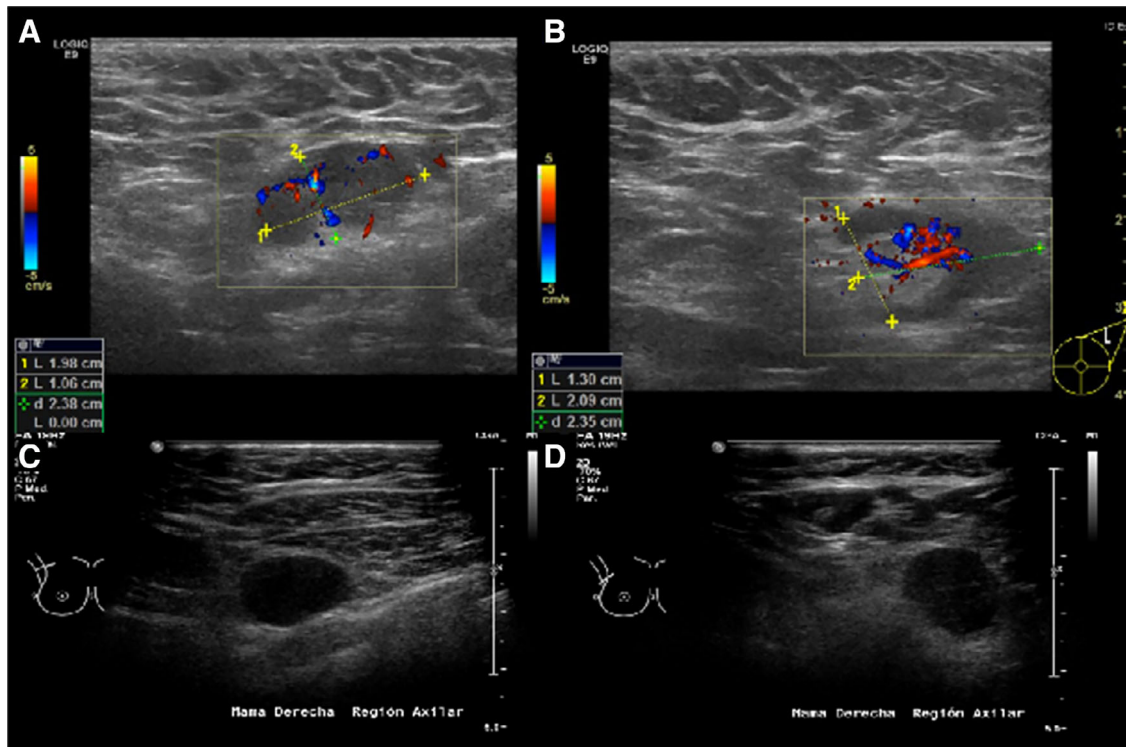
Sonographic morphologic characteristics that are predictors of malignancy. These include cortical thickness greater than 2.5–3.0 mm (A, C, D), focal cortical lobulation (B), loss of the fatty hilum (C, D), a round shape (C, D), and abnormal blood flow (A, B).
